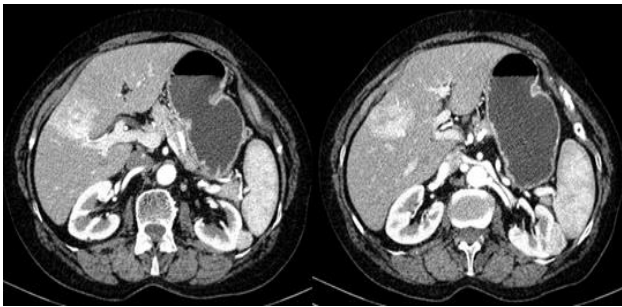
CT images, late arterial phase, showing an hypervascular tumor on the segments 5 and 8 transition, extending up to the right anterior portal pedicle (white arrow) and a similar lesion on the left kidney (black arrow).
